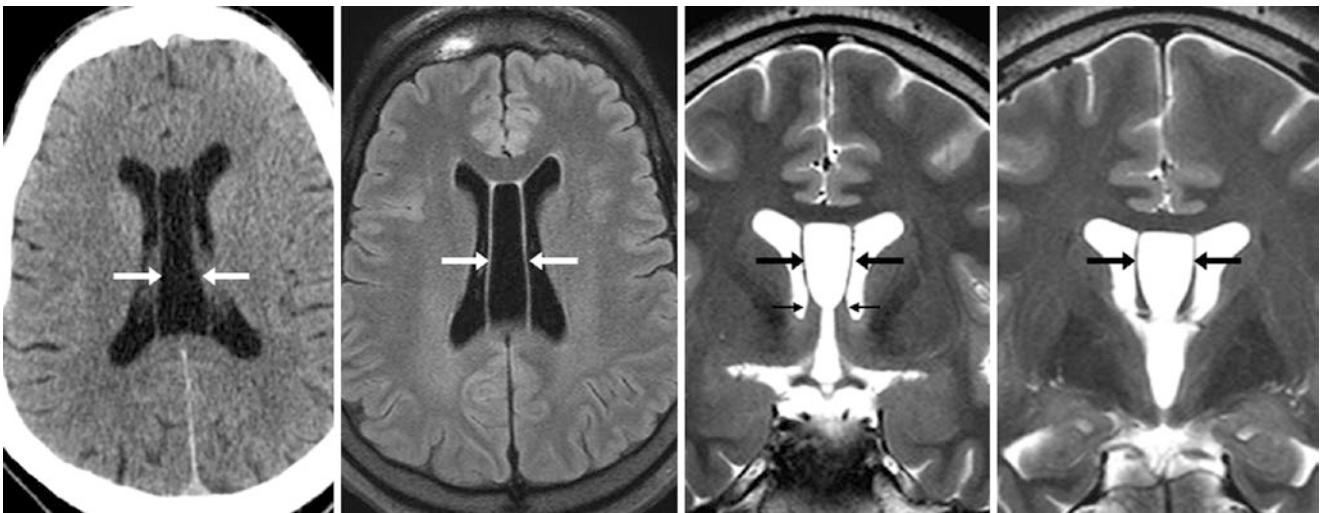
A 38 year old with a CEV on a NECT (*left*). On a 3T MRI, the extent of the CEV is demonstrated on axial FLAIR (*left middle*) and on coronal T2WIs (*right middle and right*). Note the fornical columns (*tiny arrows*)
